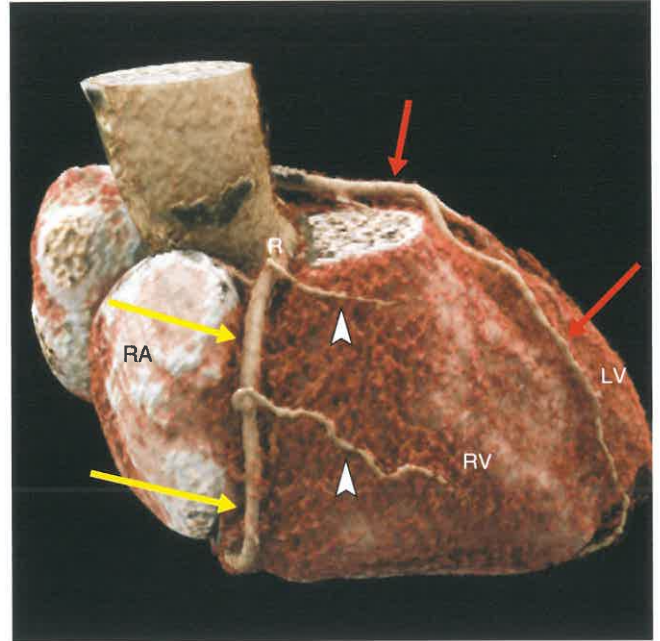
Right Coronary Artery Anatomy. Right lateral volume-rendered image from a coronary CTA shows the right coronary artery (RCA, yellow arrows) arising from the right sinus of Valsalva (R). The RCA courses in the right atrioventricular groove between the right atrium (RA) and right ventricle (RV). Acute marginal branches (white arrowheads) arise anteriorly and supply to the anterior free wall of the RV. The LAD (red arrows) can be seen coursing over the anterior wall of the left ventricle (LV).
